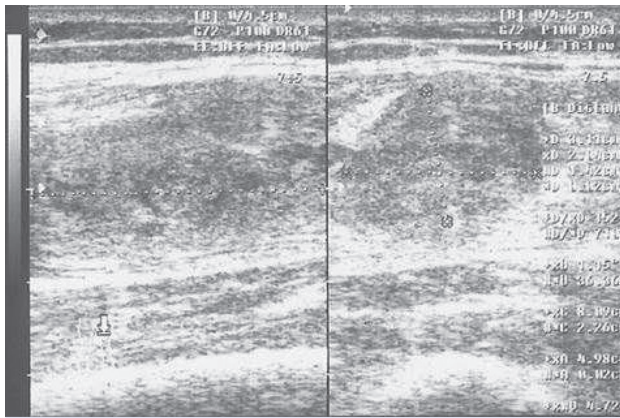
Pretreatment ultrasonographic findings.
